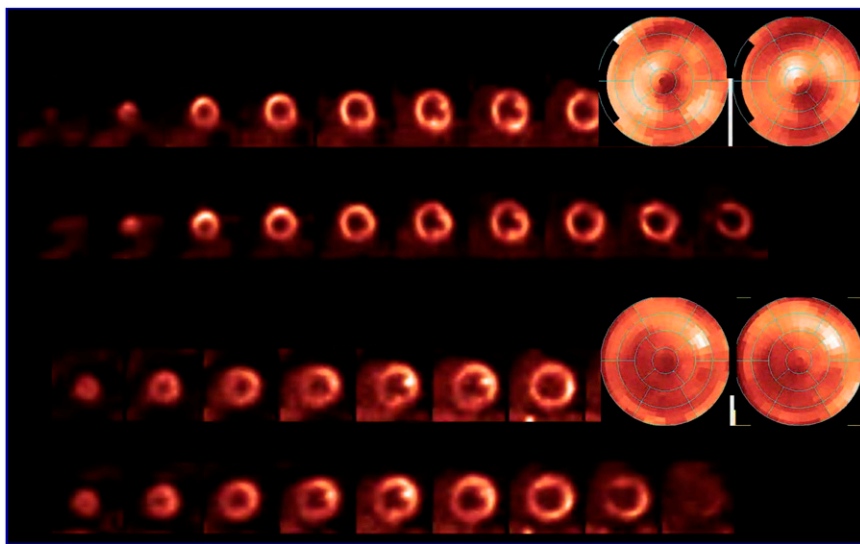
Attenuation-corrected cardiac MR/PET. Top row in each section: PET/CT; bottom row in each section: MR/PET. Larger images: left: PET/CT; right: MR/PET.
